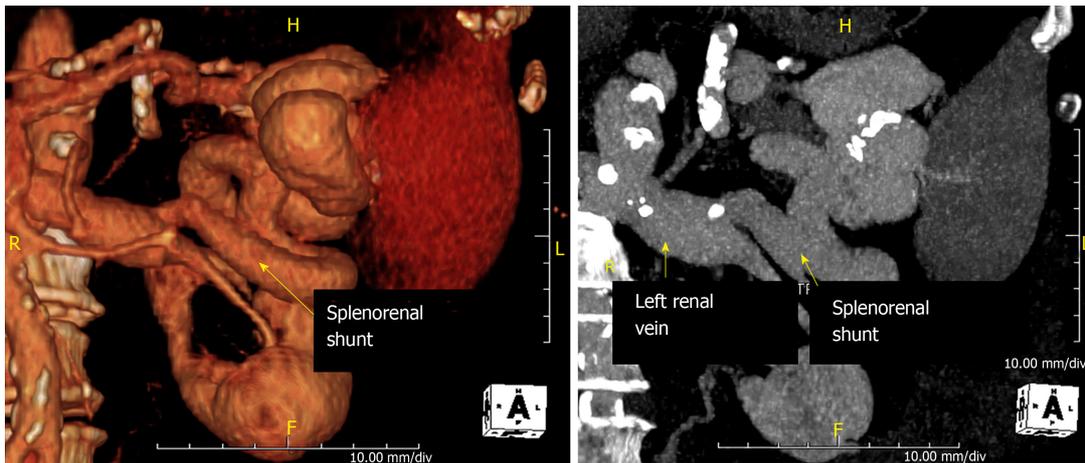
Splenorenal shunt at computed tomography scan.
